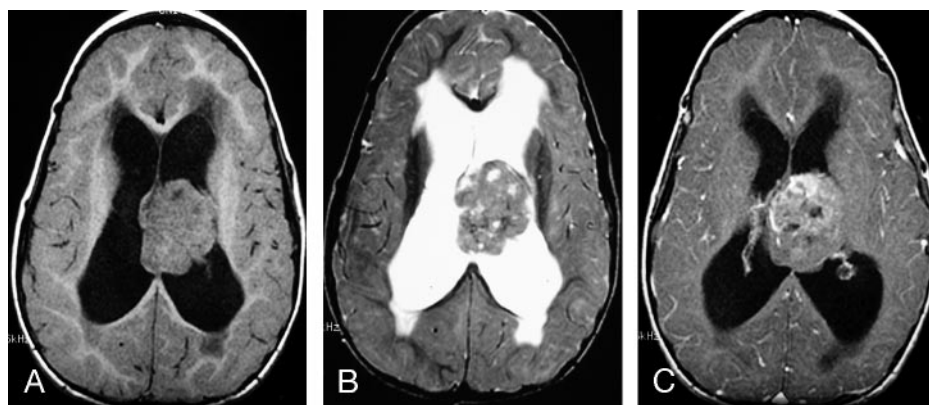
MR images of a 4-year-old girl with a constitutional ring 22 chromosome and AT/RT involving the septum pellucidum, with extension into the lateral ventricles.
